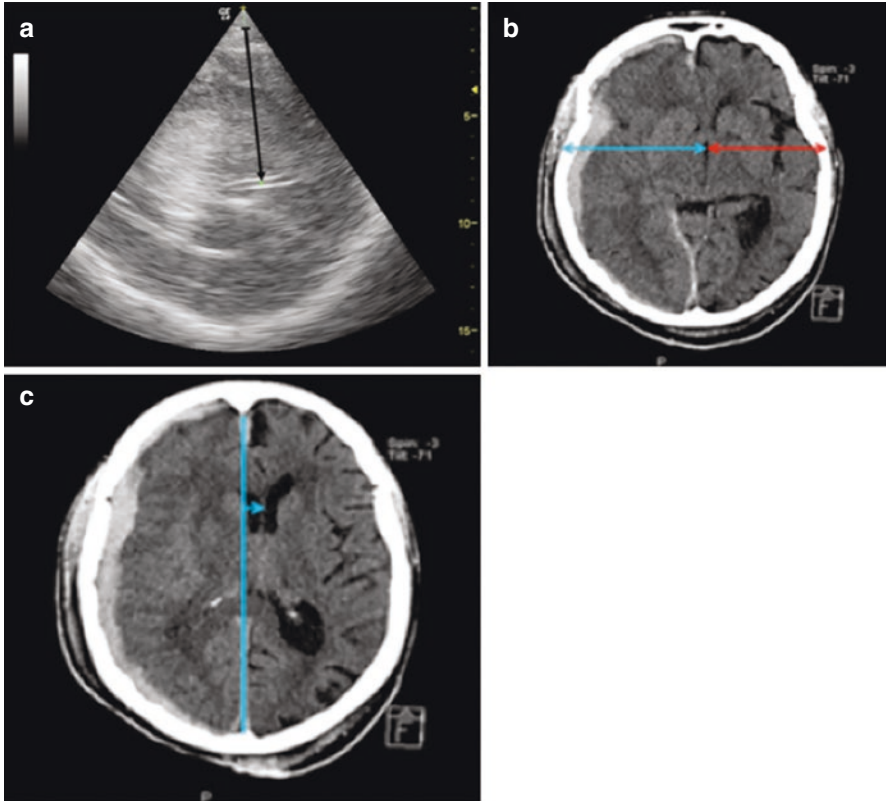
Midline shift measurement (MLS): (a) MLS measurement by TCCS through transtemporal acoustic window: (arrow) distance between external bone table (skull) and the centre of third ventricle; (b) MLS measurement by brain-CT scan: (red and blue arrow) distance between the skull and the centre of the third ventricle; (c) MLS measurement by brain-CT scan: (blue line) ideal midline and (blue arrow) distance between ideal midline and the septum pellucidum. (Coutesy: Motuel et al. [72])
